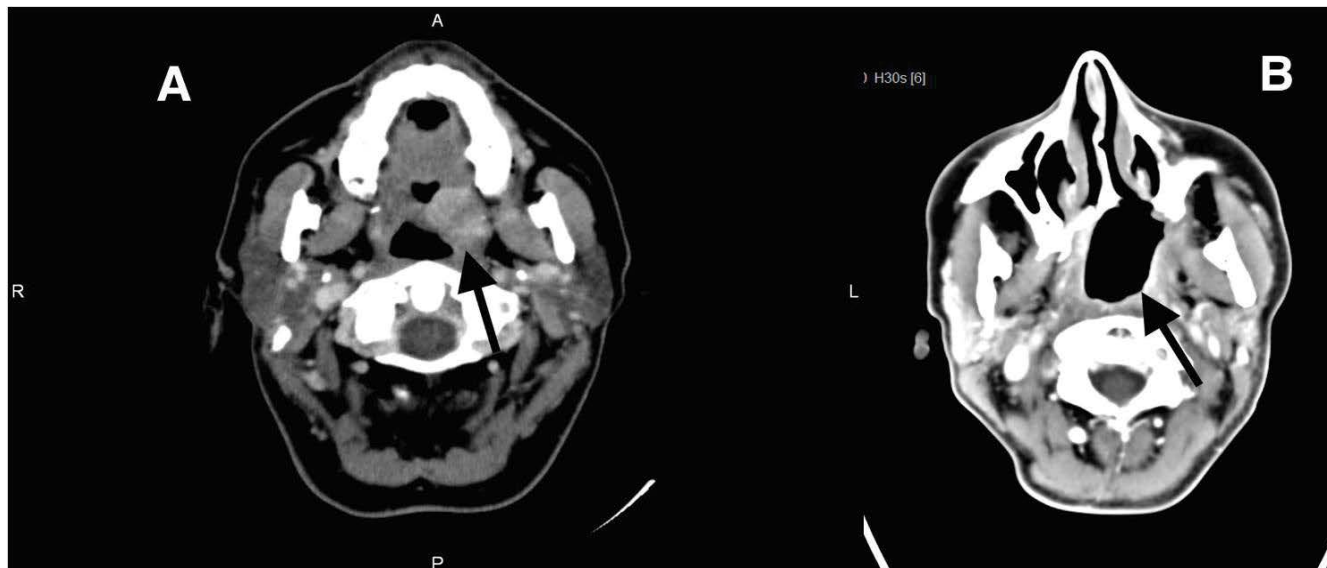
Axial contrast-enhanced CT images in the 45-year-old patient with the T3N0M0 carcinoma of the left soft palate. (A) Contrast-enhancing tumour of left soft palate (arrow); (B) Post-surgery CT image obtained 6 months after completion of radiochemotherapy. No evidence of locoregional recurrence is visible (arrow).
